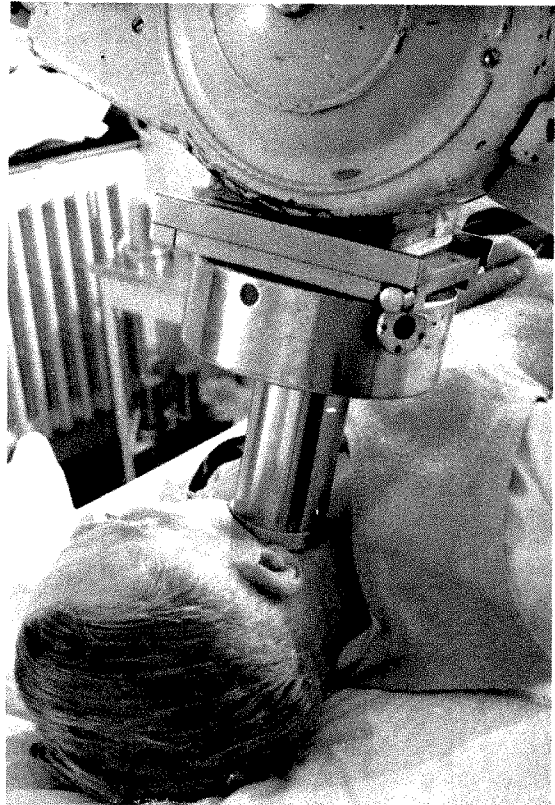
High voltage (250 kv.) roentgen-ray therapy. Note that the circular cylinder is pressed firmly against the patient's neck to prevent any motion during the treatment period.
